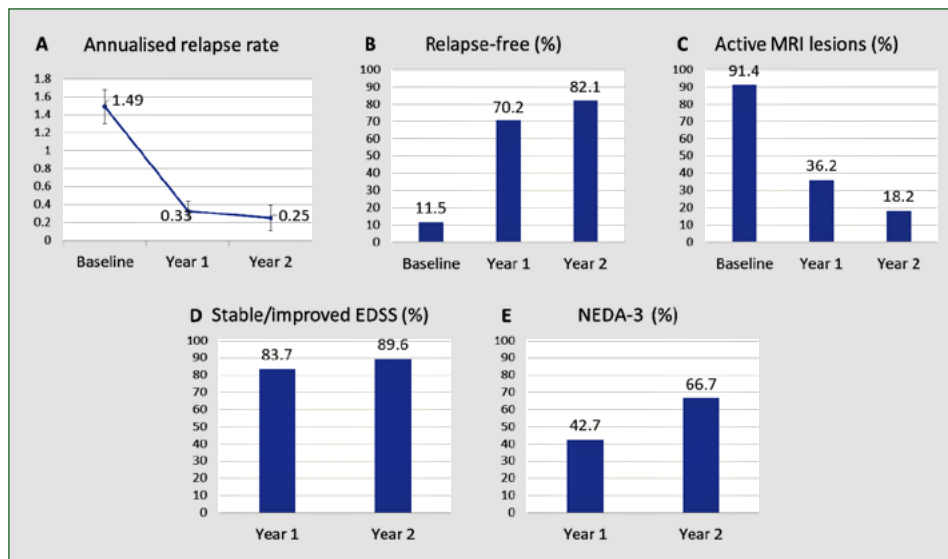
Efficacy outcomes after treatment with cladribine tablets. A. Annualised relapse rate — point estimates are means and error bars are standard deviations. B. Percentage of relapse-free patients. C. Percentage of patients with active MRI lesions. D. Percentage of patients with stable/improved EDSS. E. Percentage of patients with NEDA-3. Denominators at baseline, year 1, and year 2 were as follows: A and B (139, 94, 28); C (139, 80, 22); D (-, 86, 29); E (-, 89; 24). EDSS — Expanded Disability Status Scale; MRI — magnetic resonance imaging; NEDA-3 — No Evidence of Disease Activity 3
